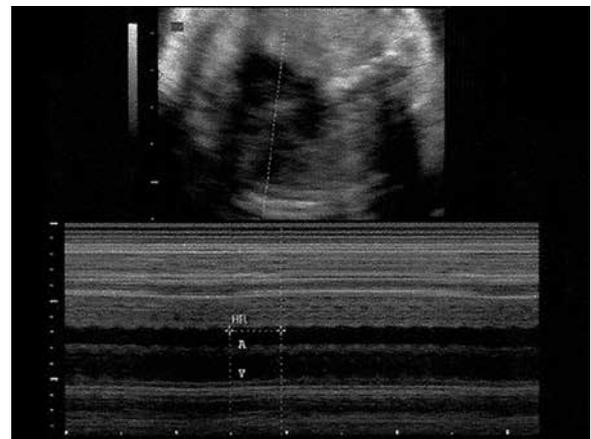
Fetal echocardiogram. Atrial rate of 257 bpm, with rare supraventricular extrasystoles. Source: Patient's ultrasound described in this case report.
